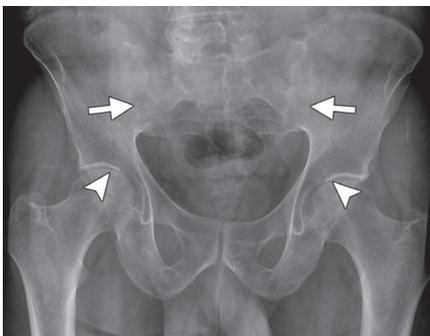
Anteroposterior radiograph of the pelvis with ankylosing spondylitis shows total ankylosis (fusion) of both sacroiliac joints (arrows) and uniform narrowing of the hip joints (arrowheads).
